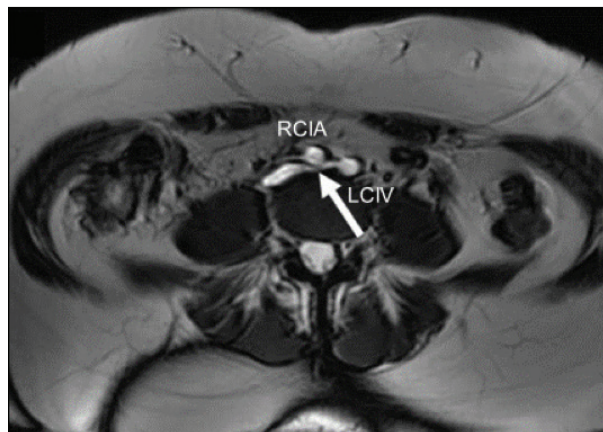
T2-weighted MRI demonstrates LCIV compression by the RCIA (arrow), characteristic of May-Thurner syndrome.
